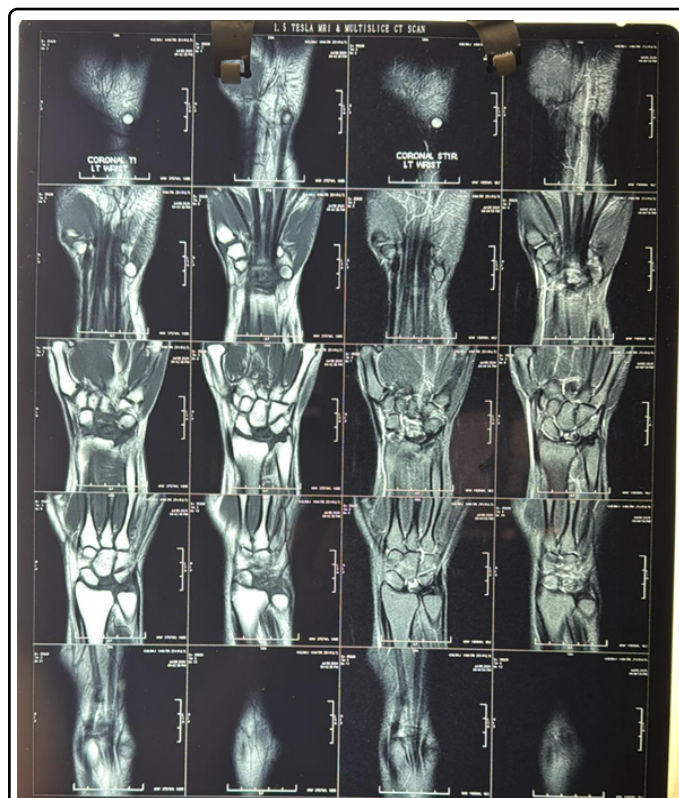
MRI showing stage III b of Kienböck's disease. Irregular loss of articular cartilage of proximal lunare.
